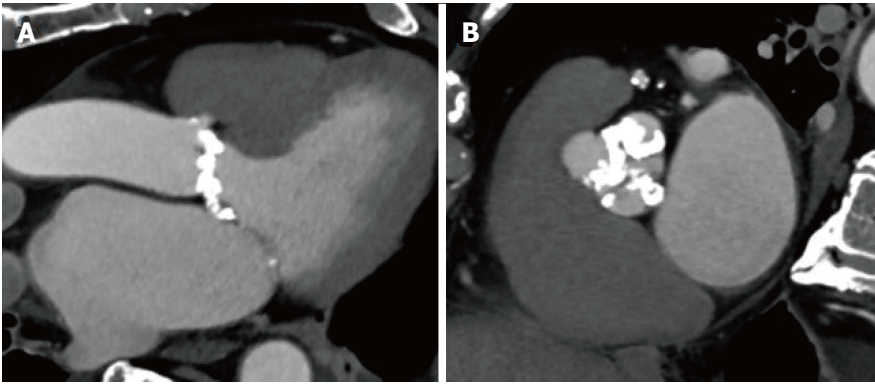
Cardiac multislice computed tomography showing a patient with heavy calcifications extending into the left ventricular outflow tract and a shallow sinus. This anatomy is associated with increased risk for annular rupture in patients undergoing TAVI with a balloon expandable valve. A: Three chamber view of the heart showing a patient with heavy calcification extending from the aortic annulus into the LVOT and a shallow sinus; B: Short axis view of the aortic valve showing heavy calcified aortic leaflets. LVOT: Left ventricular outflow tract; TAVI: Transcatheter aortic valve implantation.
